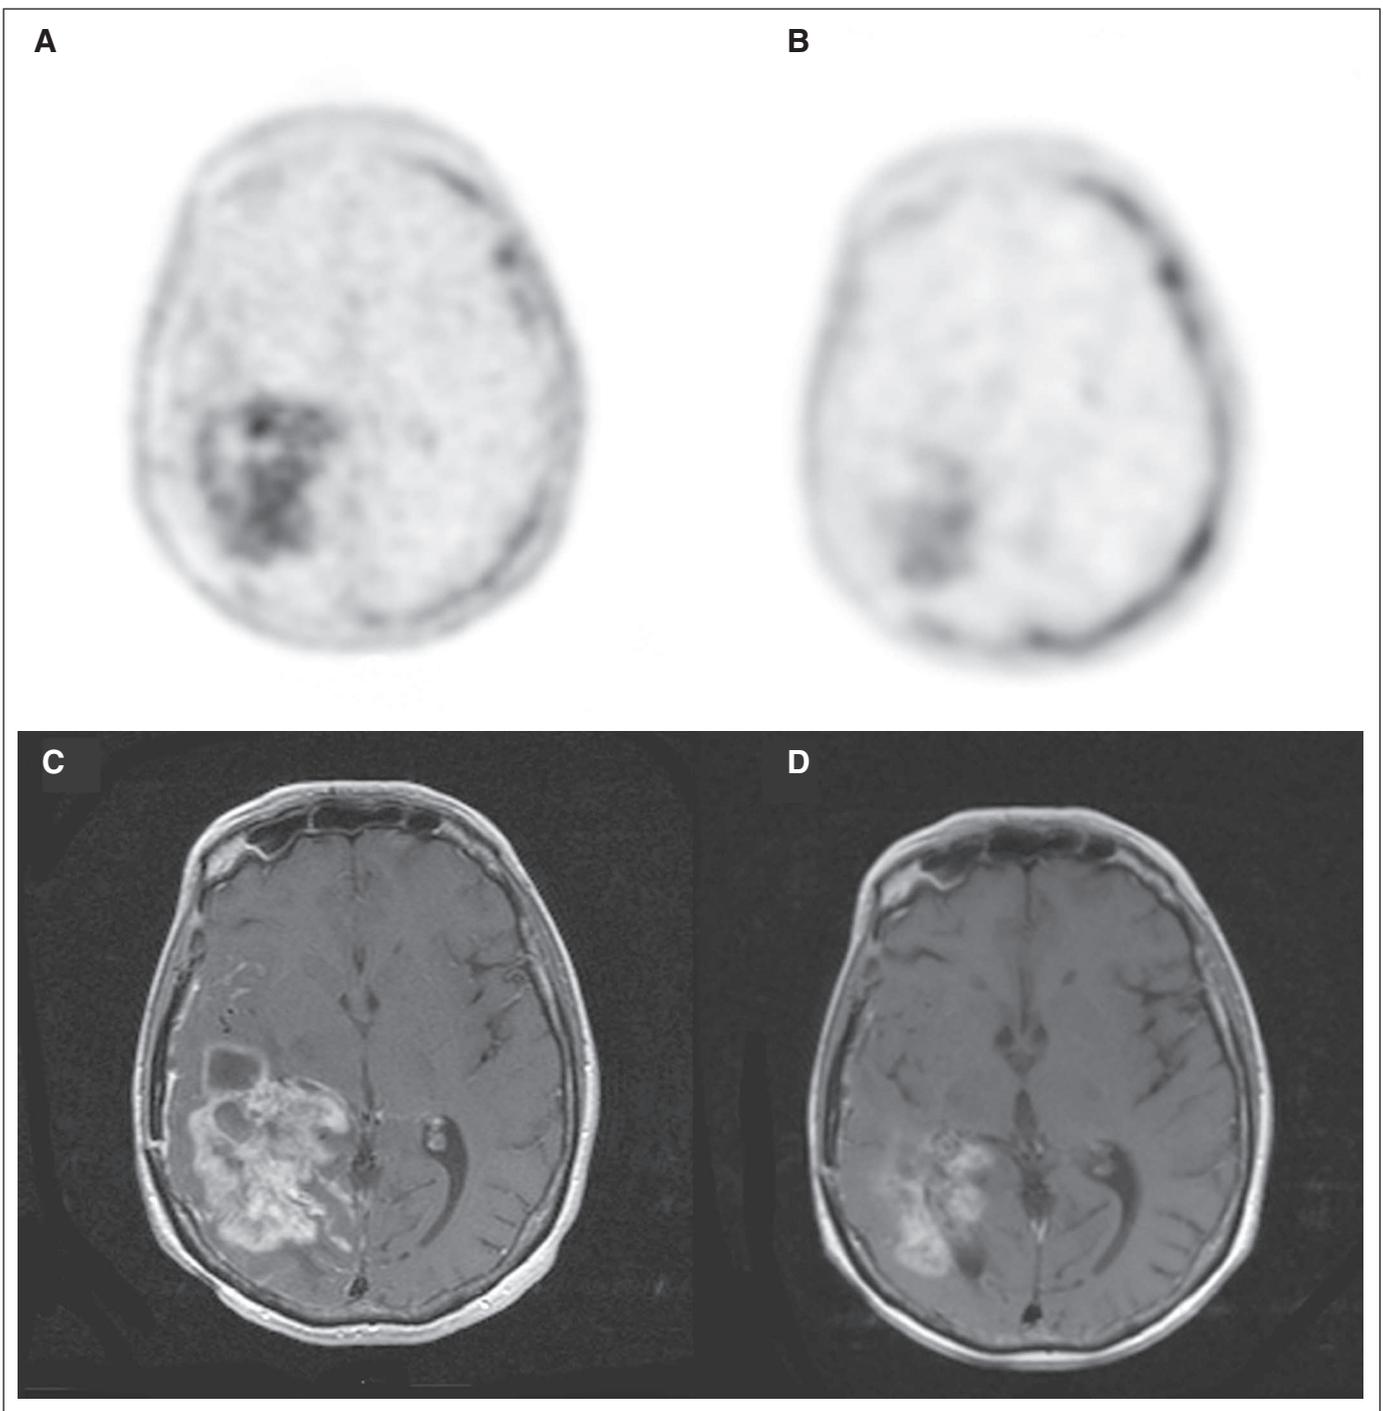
Patient (No. 8) classified by FLT-PET as responder at 1 week but stable disease by magnetic resonance imaging (MRI) at 6 weeks. Response by MRI occurred at 3 months. Upper panel shows [^{18}F] fluorothymidine (FLT) positron emission tomography (PET) slices (A) before and (B) 1 week after starting treatment. Lower panel shows MRI images (C) before and (D) 3 months after starting treatment.
